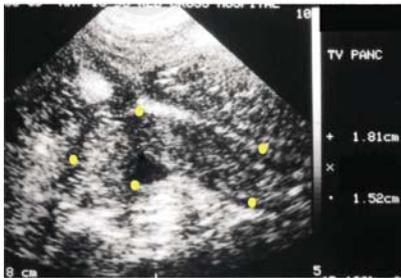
Ultrasound of the pancreas – swollen, enlarged inhomogeneous pancreas due to traumatic pancreatitis
